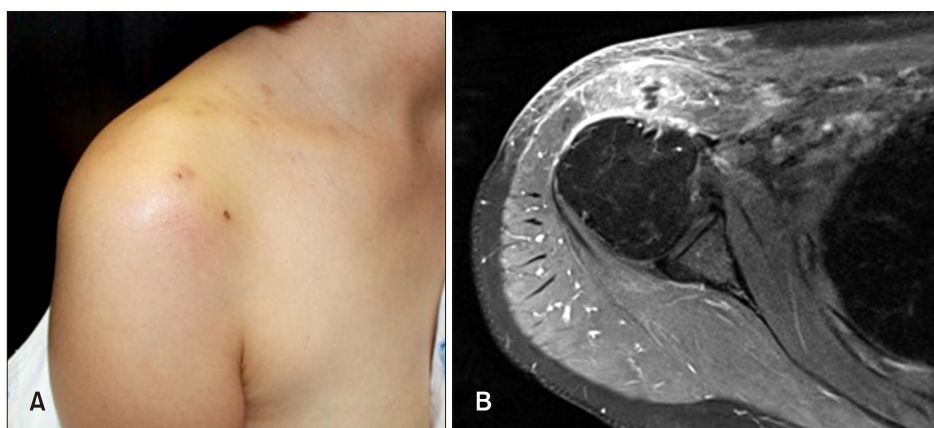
(A) A 41-year-old woman with a localized, ill-defined, tender, erythematous, indurated plaque on her right shoulder. (B) Transverse T1-weighted magnetic resonance imaging demonstrated swelling and increased signal intensity with enhancement in the deltoid and coracobrachialis areas and diffuse subcutaneous edema in the anterior shoulder.
